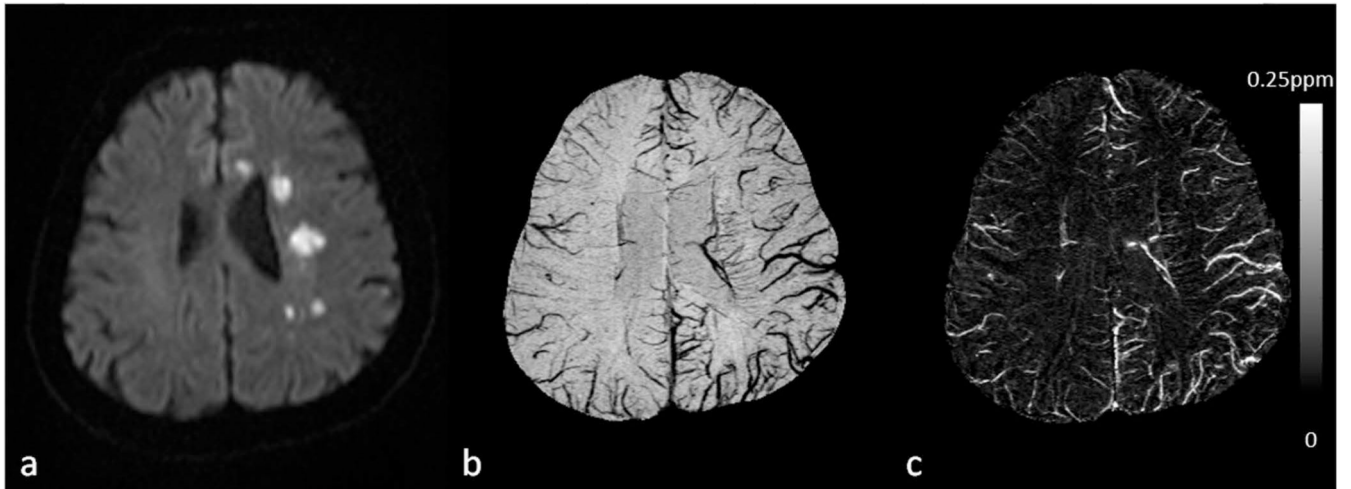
Visualization and quantification of asymmetrically prominent cortical veins (APCV) in an ischemic stroke patient using SWI and QSM. a. DWI showed multiple high signal regions in the centrum semiovale and in the genu of the corpus callosum. b. Visualization of the APCV in the left hemisphere in the minimum intensity projection of SWI data. c. Maximum intensity projection of susceptibility maps showing cortical veins with increased susceptibility in the ischemic hemisphere, compared to those in the contralateral hemisphere. Susceptibility maps were generated using the geometry constrained iterative SWIM algorithm (65).
